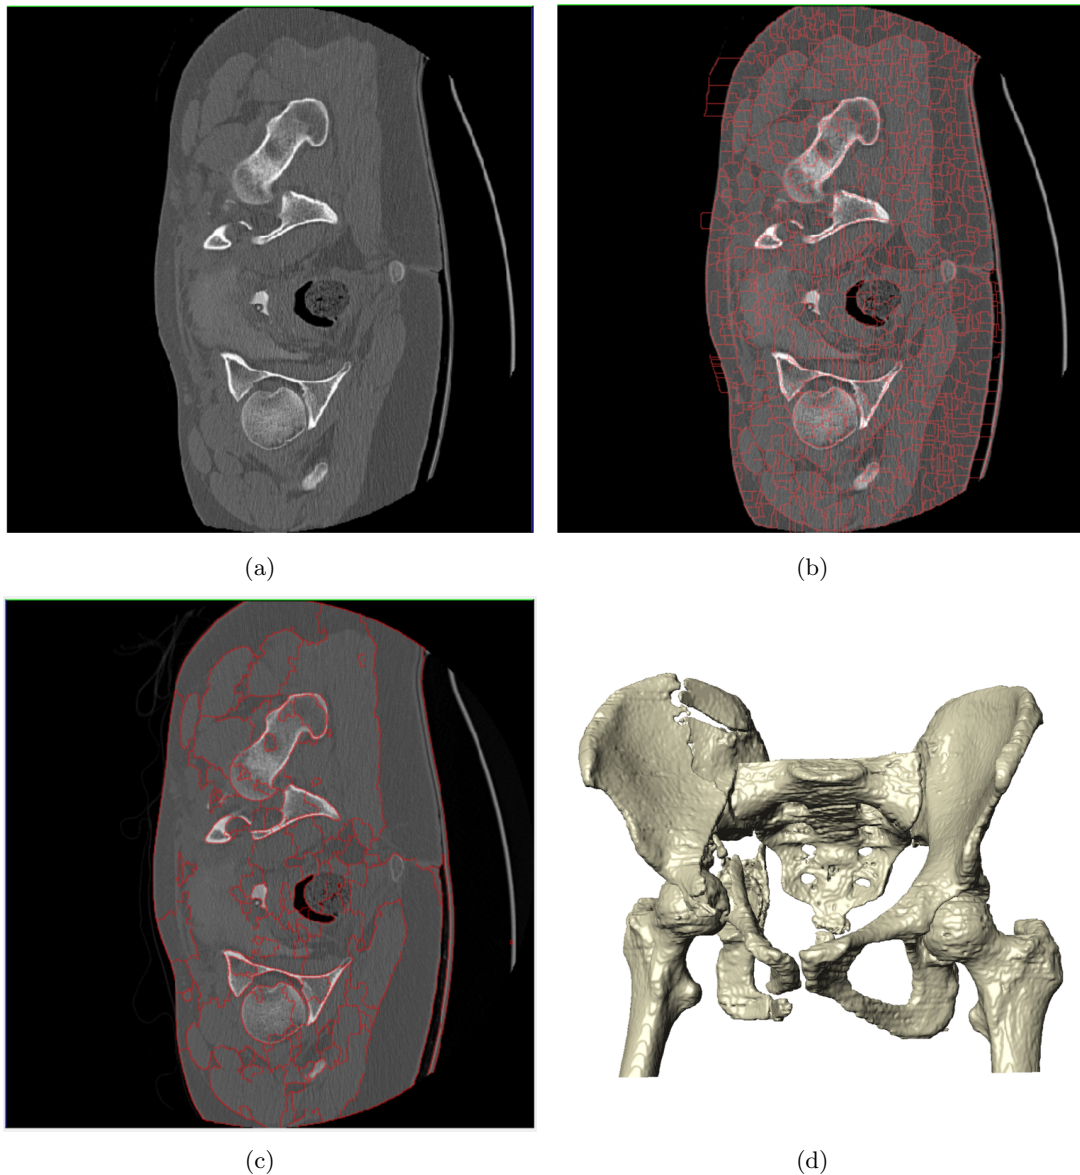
In (a) pelvic bone imaged acquired with CT, in (b) watershed lines obtained from the gradient of the image, in (c) marker-controlled watershed segmentation, and in (d) the final 3D model obtained with the marker-controlled watershed segmentation
